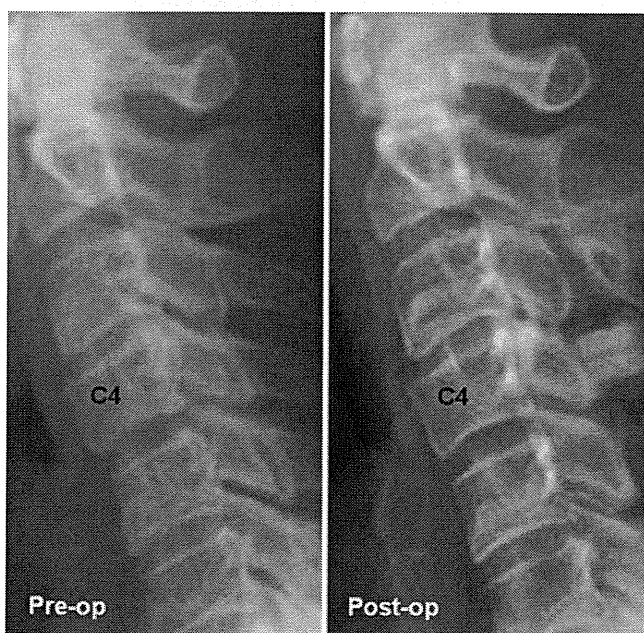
Case 2. Plain lateral radiographs showing the localized type of OPLL at C-4. It was difficult to recognize ossification on the preoperative radiograph (left). The postoperative radiograph (right) shows ossification; however, the length of progression was unclear.
